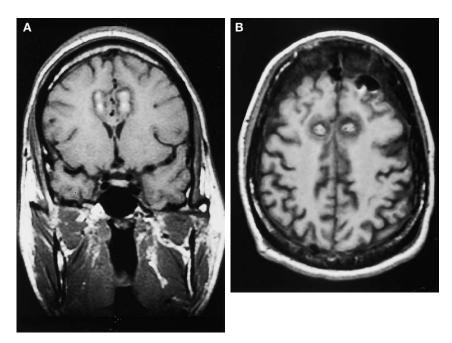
Midsagittal (A) and axial (B) T1-weighted MRI scans obtained 48 hours after a single anterior cingulotomy lesion. The acute hemorrhagic lesion undergoes a dramatic reduction in size as the edema resolves.
